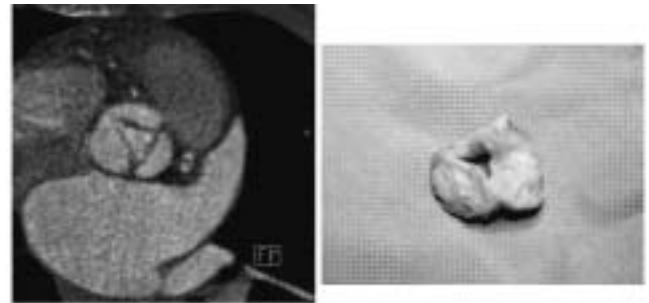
Comparison of aortic valve stenosis at 64-slice CT (left) and at surgery (right).
